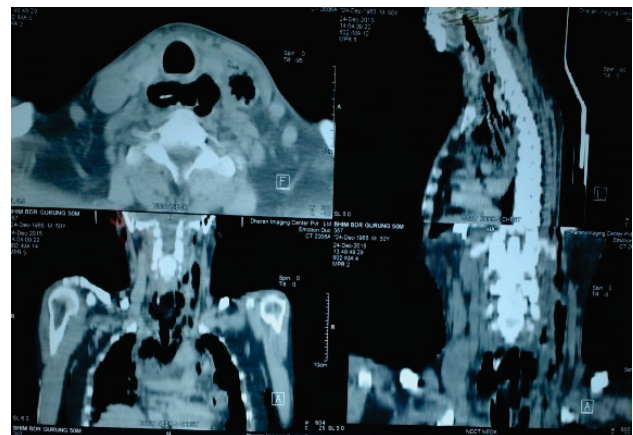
CT Scan Neck and chest showing Complication of FB Esophagus (Neck Abscess & Mediastinitis)
